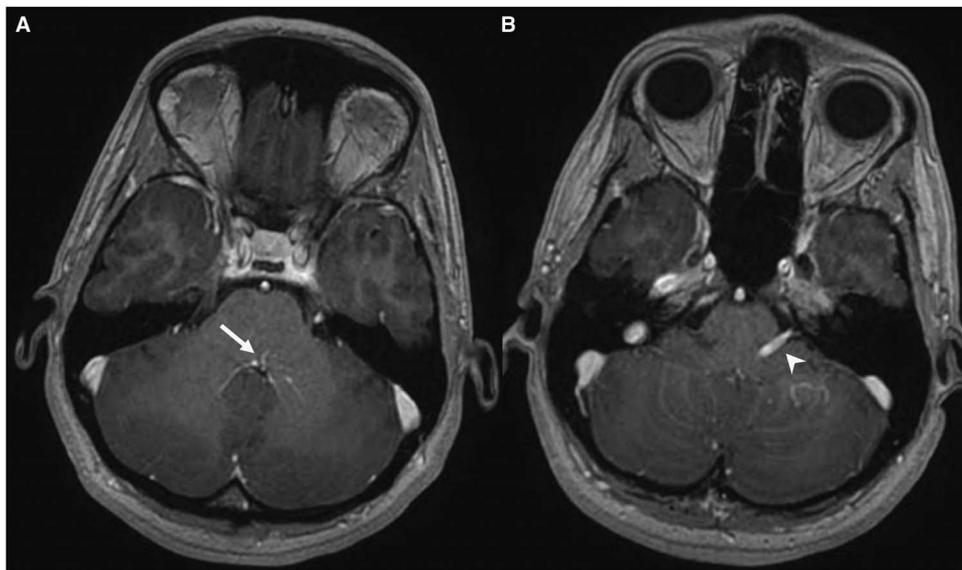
Two selected images from axial post-contrast 3D T1 MRI sequence acquisition show a tuft of tributary veins, or “caput medusae” (A, arrow), consistent with a developmental venous anomaly¹⁴, in the left posterior pons near the fourth ventricle leading to the larger draining abnormal vein (B, arrowhead) which is seen apposed to the left 7th cranial nerve in its root exit zone in the cerebellopontine angle cistern. There was no infarction, hemorrhage, mass or other relevant finding on the study.
